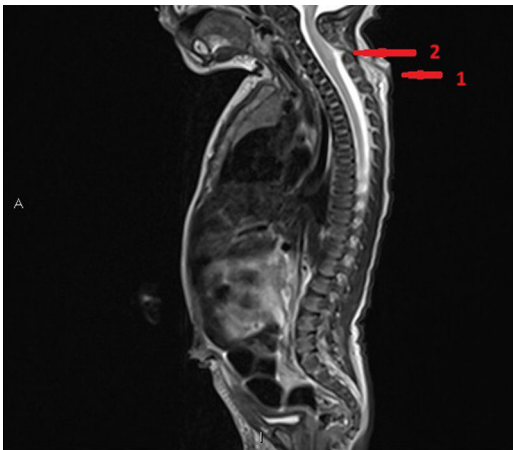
Magnetic resonance imaging. Arrow 1: visualization of ascending tract reaching the thecal sac, which is slightly dilated. Arrow 2: slightly dilated thecal sac at the level of C4-C5 with spinal cord slightly tethered toward it, including the meninges.
